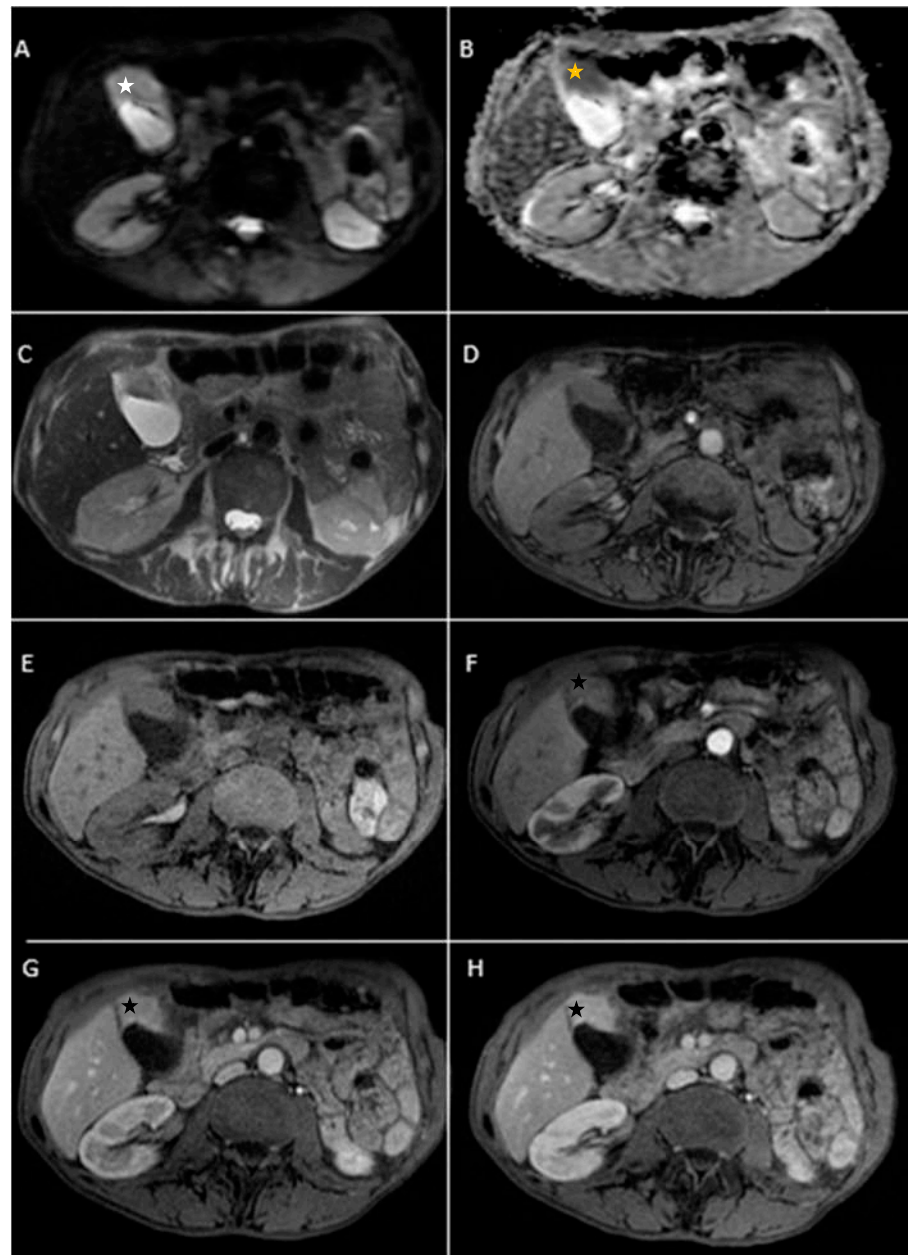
Abdominal MRI sequences highlighting gallbladder carcinoma. (A) Diffusion-weighted imaging (DWI B800) showing areas of moderate-high signal of the intraluminal gallbladder mass located in the fundus area (white star). (B) On ADC map, the intraluminal gallbladder mass is dark—diffusion restriction (yellow star). (C,D). Axial T2-weighted showing distended gallbladder with a heterogeneous hypointense intraluminal mass and axial T1 dual ECHO showing isointense gallbladder mass. (E) Axial T1-weighted image showing isointense gallbladder mass. (F–H). Axial contrast-enhanced T1-weighted image (arterial phase followed by venous phase) showing strong contrast-enhancement of the intraluminal gallbladder mass (black star).
